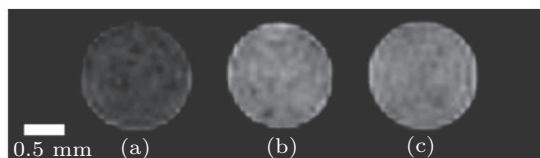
MR images (T_1 -weighted). The scale bar represents 0.5 mm (at 14.1 T within an FOV of 20 mm and a slice thickness of 0.5 mm). The T_1 values are calculated via the student t tests at a 95% confidence level. (a) Control PC3M cells ($T_1 = 3527 \pm 48$ ms); (b) PC3M cells incubated with 0.001 mM DNA-DOPA-DO3A NPs with 1.8% 1:TiO₂ active site coverage ($T_1 = 2178 \pm 88$ ms); (c) PC3M cells incubated with 0.001 mM DNA-DOPA-DO3A NPs with 4.4% 1:TiO₂ active site coverage ($T_1 = 2356 \pm 100$ ms).^[142]
